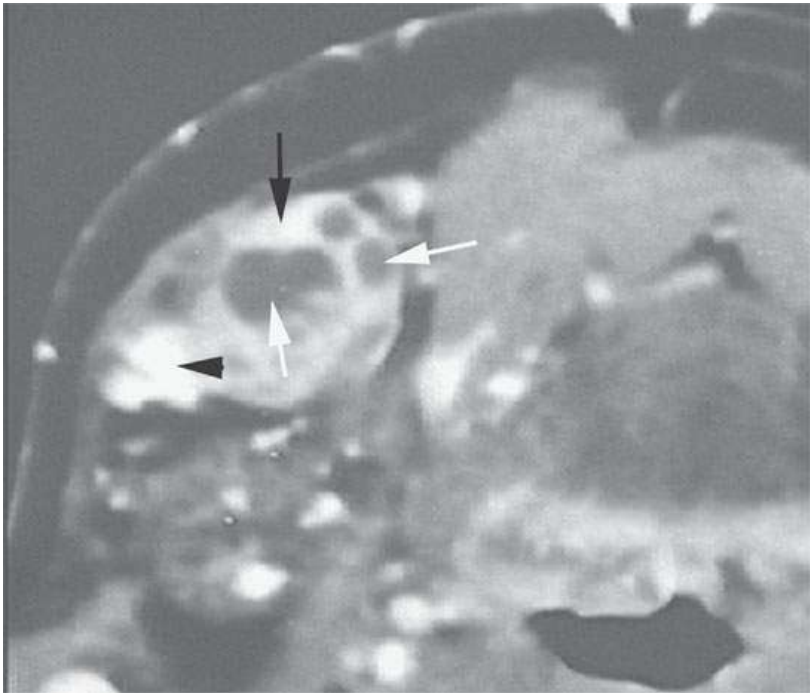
Contrast-enhanced computed tomography of squamous cell carcinoma metastatic to a level 1 lymph node showing focal enhancement (*black arrow*), focal lucencies (*white arrows*), and focal calcification or keratin debris (*arrowhead*)—all indicators of metastatic disease.
